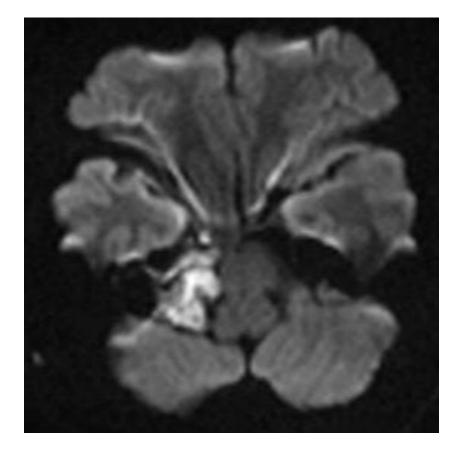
CPA Epidermoid cyst. Complementary plain MRI axial diffusion weighted image in the same patient shows a lobulated lesion at the right CP angle showing diffusion restriction (arrow), suggestive of epidermoid cyst. The lesion was similar to CSF intensity on MRI.
